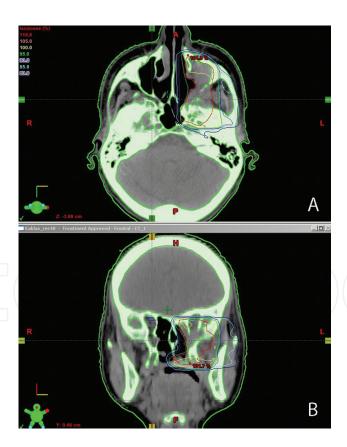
Representative isodose plan for patient undergoing reirradiation: (A) axial and (B) coronal CT slice. The patient had recurrent grade 3 adenoid cystic carcinomas of hard palate previously treated to 60 Gy with concurrent cisplatin. A local recurrence developed after 15 months, and the patient underwent reirradiation with IMRT to 48 Gy. The clinical and planning target volumes are showed in red, the total cumulative dose to brainstem was 51.54 Gy, spinal cord—42.1 Gy, chiasma—50.4 Gy, n. opticus left—51.2 Gy. No late toxicity was observed after 1 year.
